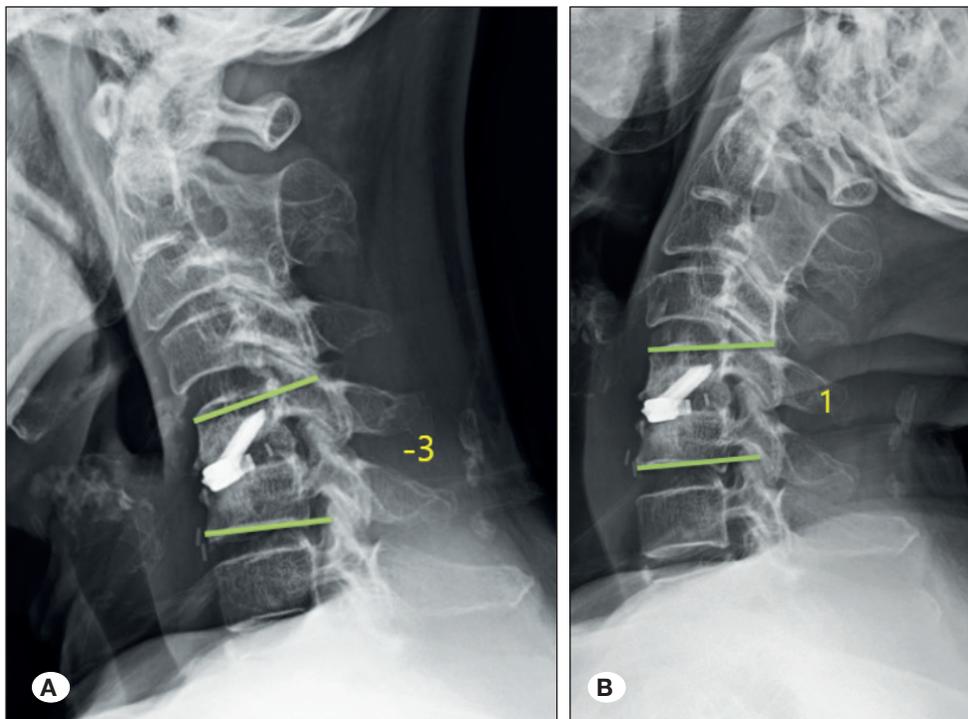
Lateral view of standard cervical radiography of a patient operated on with an anchored cage. CL represents the angle (°) between the lower edge of the C2 and C7 vertebrae; SA represents the angle (°) between the upper edge of the cranial vertebral body and the lower edge of the caudal vertebral body at the surgical level. SVA is the distance between the vertical line away from the C2 center and the posterior upper edge of the C7 vertebral body. (A) AP: anteroposterior length; SVA: sagittal vertical axis.
